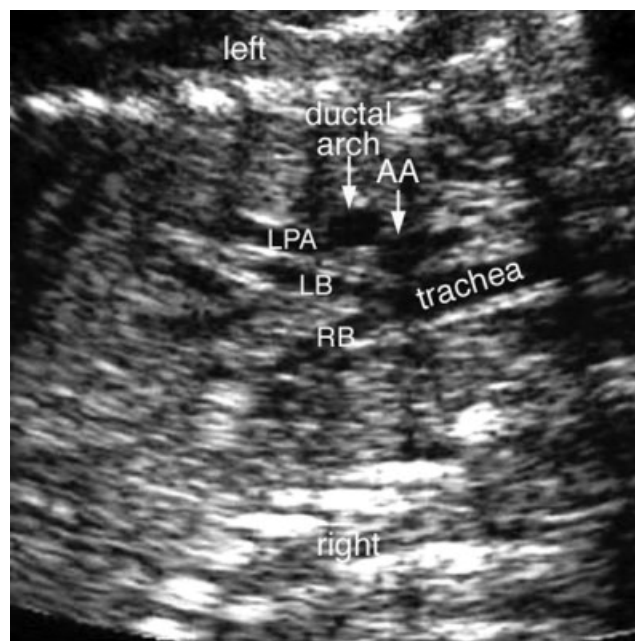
Coronal sonogram of the chest showing bifurcation of the trachea into the right (RB) and left (LB) main bronchi. Both aortic arch (AA) and ductal arch are seen on the left side of the trachea in this normal fetus. LPA, descending branch of the left pulmonary artery.
